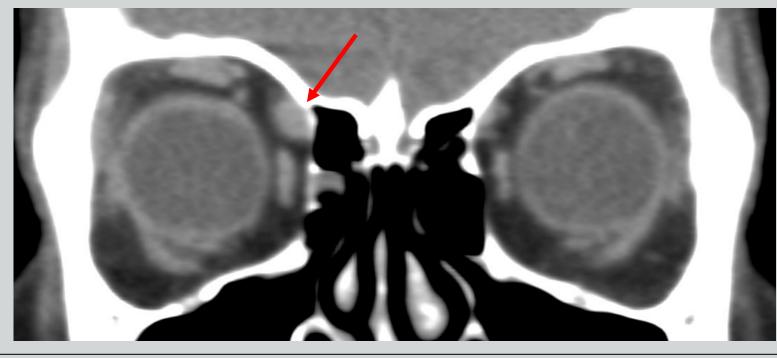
Patient with right eye acquired Brown's syndrome shows severe limitation of right eye elevation in adduction. CT Scan shows large right superior oblique muscle consistent with myositis. (Red arrow)
